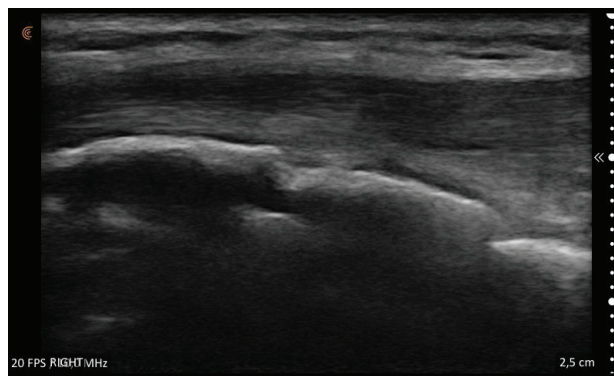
Ultrasound picture of the same right knee, 3 months after the three injections. Fewer deformations and inflammation are visible.
